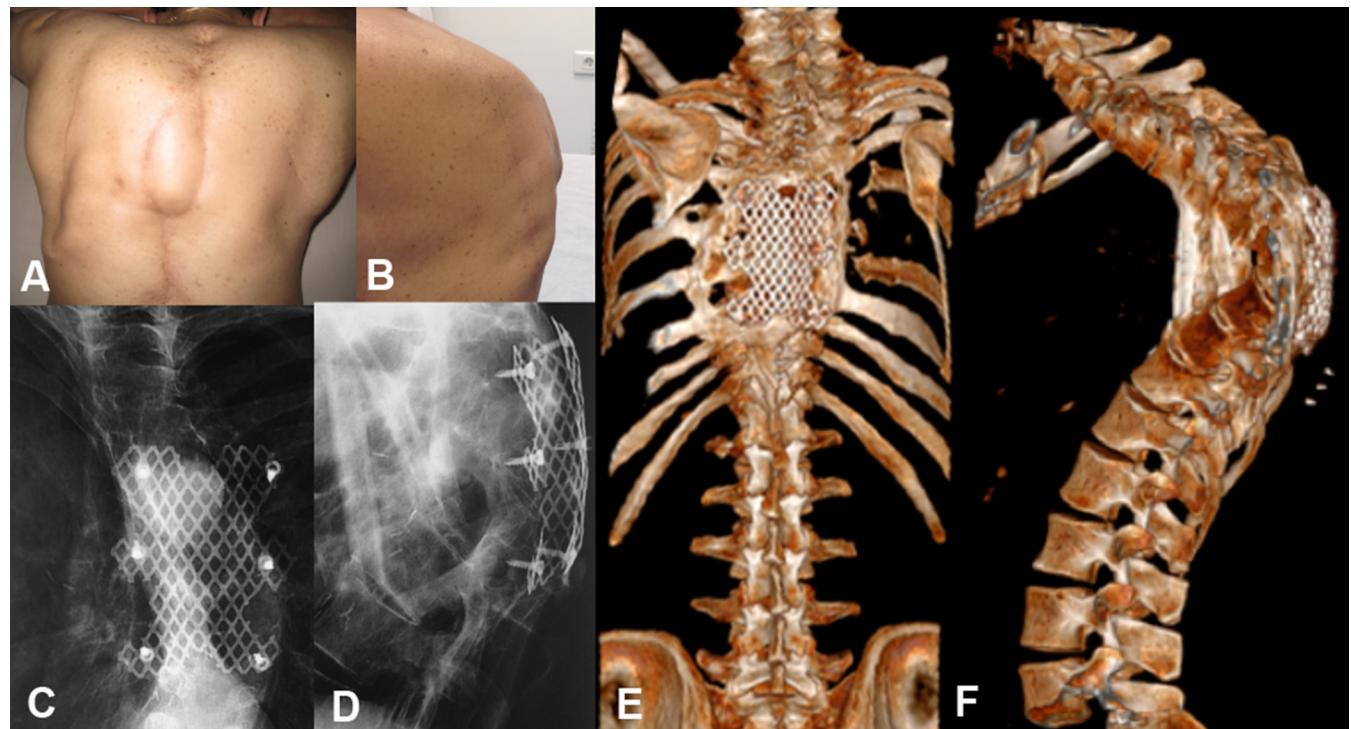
Dorsal (A) and lateral (B) views of skin evolution. Spinal shield remaining intact at 5 years follow-up, based on plain X-ray in posterior-anterior (C) and lateral views (D), and on 3-D CT scan reconstructions (E and F).
